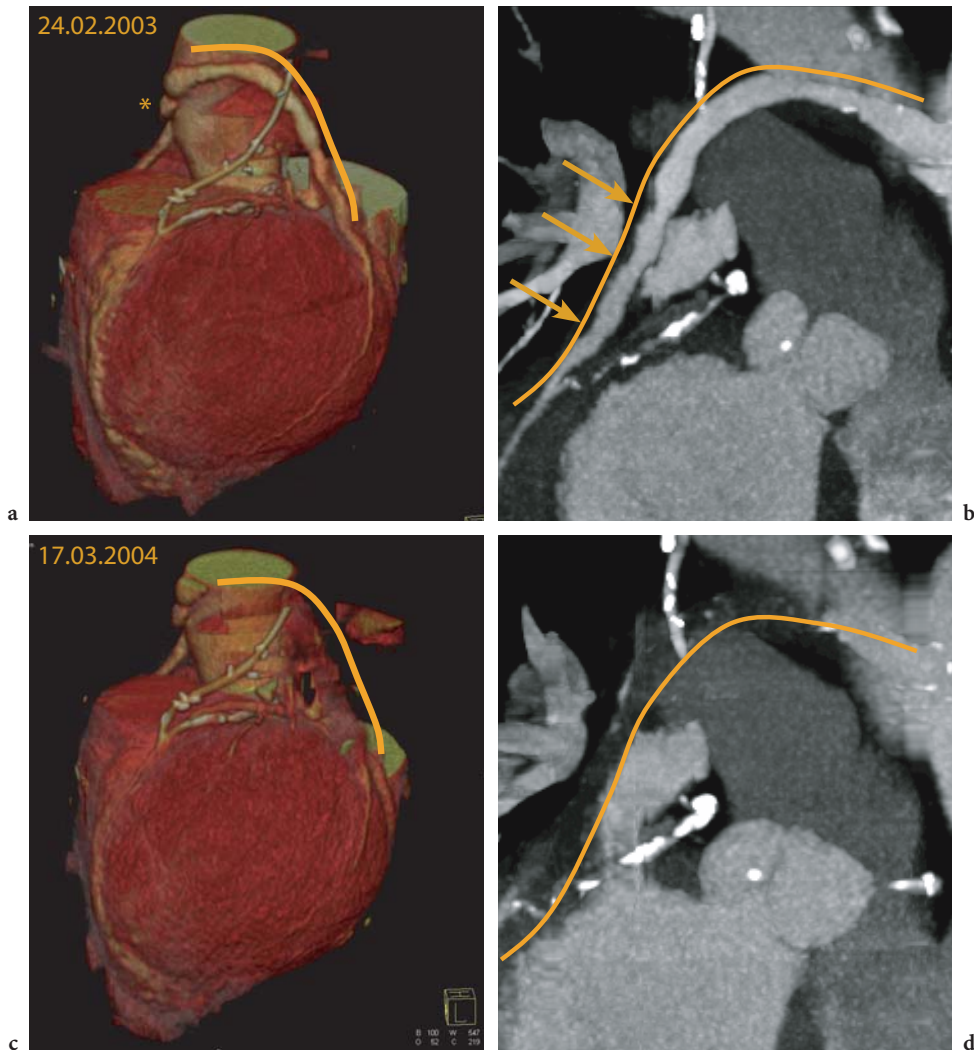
Patient examined with 16-slice CT with triple venous bypass grafts on the RCA, CX, and D1, and an additional internal mammary artery (*IMA*) graft on the LAD. Prior to the first scan in 2003 (a VRT, b curved MIP) a total occlusion of the venous graft on D1 was known (marked by *). All other grafts were fully patent. On the follow-up scan 1 year later, the large graft on the CX is also occluded (c VRT, d curved MIP). Orange lines indicate the original course of the occluded D1 venous graft (a–d). The first scan demonstrates non-calcified graft angiopathy (b, arrows)
